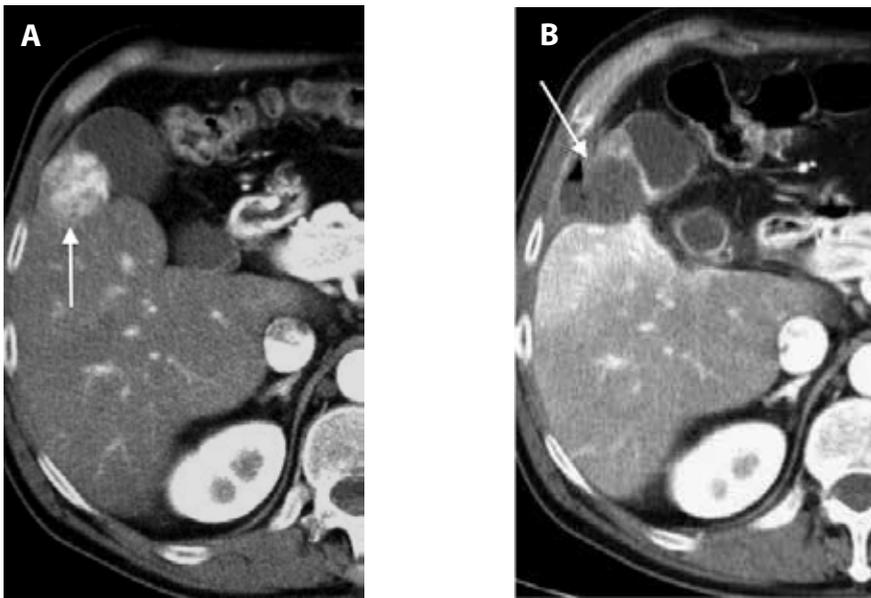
a) CT image before treatment; b) CT image post treatment that shows complete ablation
